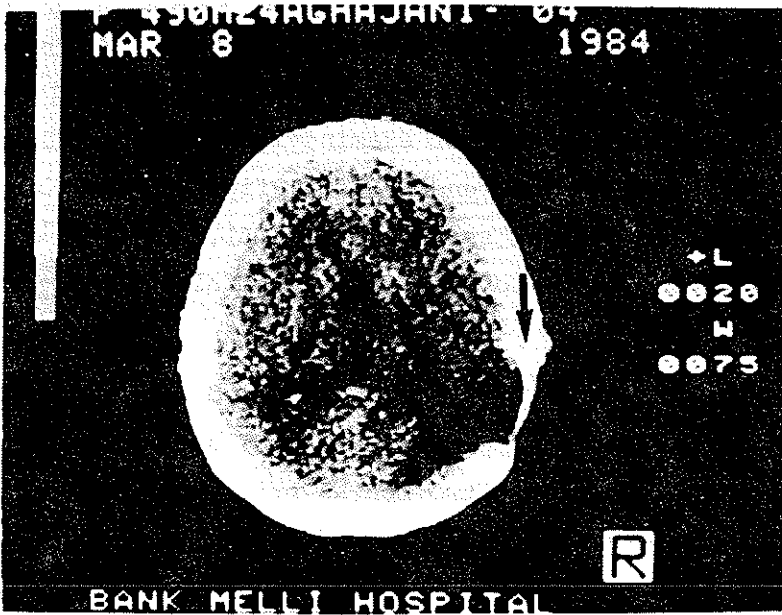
CT Scan showing the right occipital lesions (small arrows). An important occipital bone defect is also evident (arrow). This patient had a left homonymous hemianopia.
